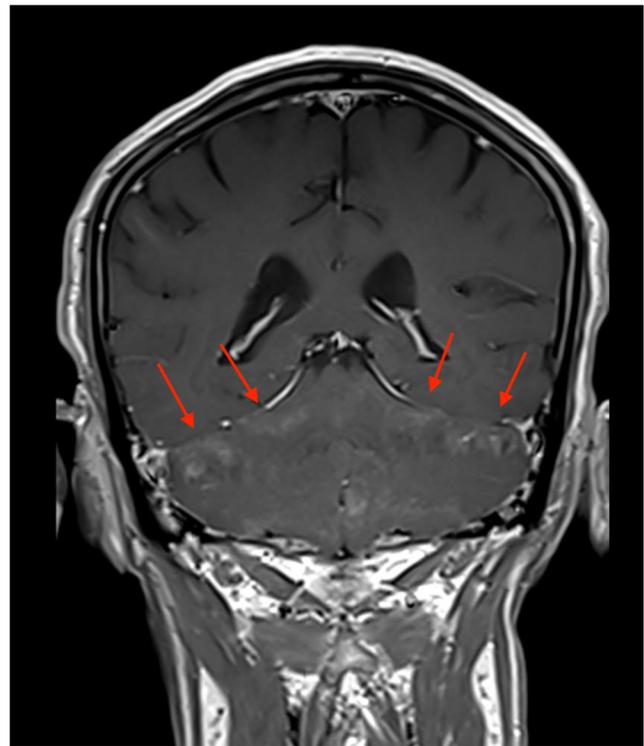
Imaging at presentation. Coronal T1-weighted imaging after the intravenous administration of contrast demonstrates patchy enhancement of the cerebellar hemispheres peripherally (red arrows) corresponding with the subarachnoid space and leptomeningeal surfaces
